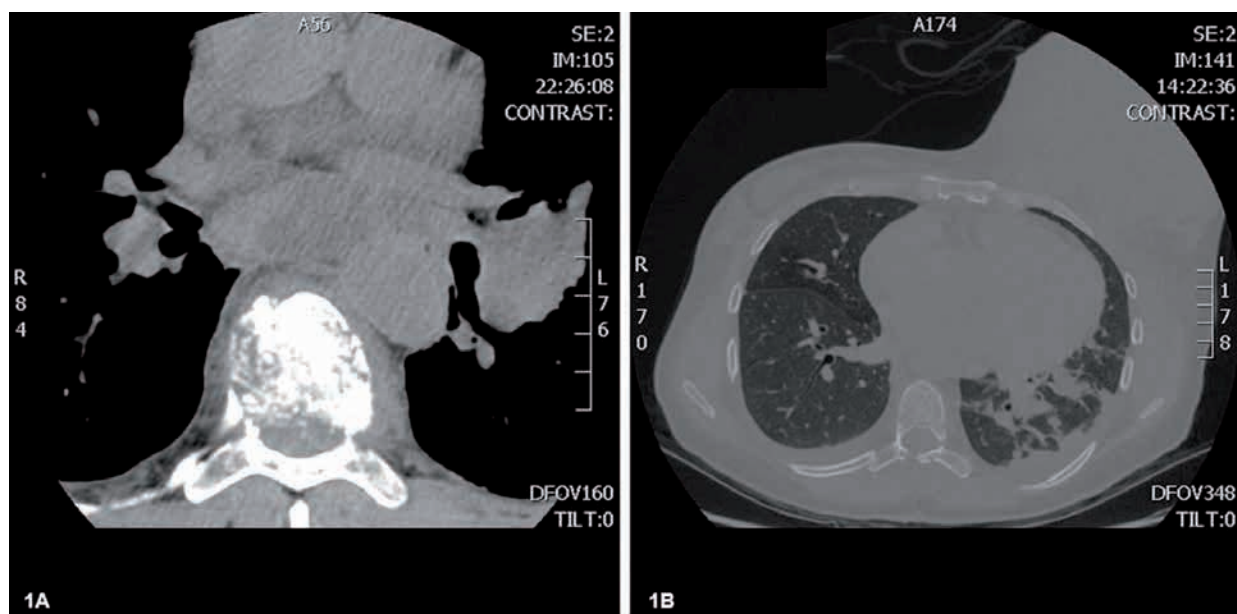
The computed tomography findings of spine and chest. 1A, Destruction of the Th7 vertebra. Note the compression of the spinal cord. 1B, Large mass of the left breast and pathological changes in the left lung.
